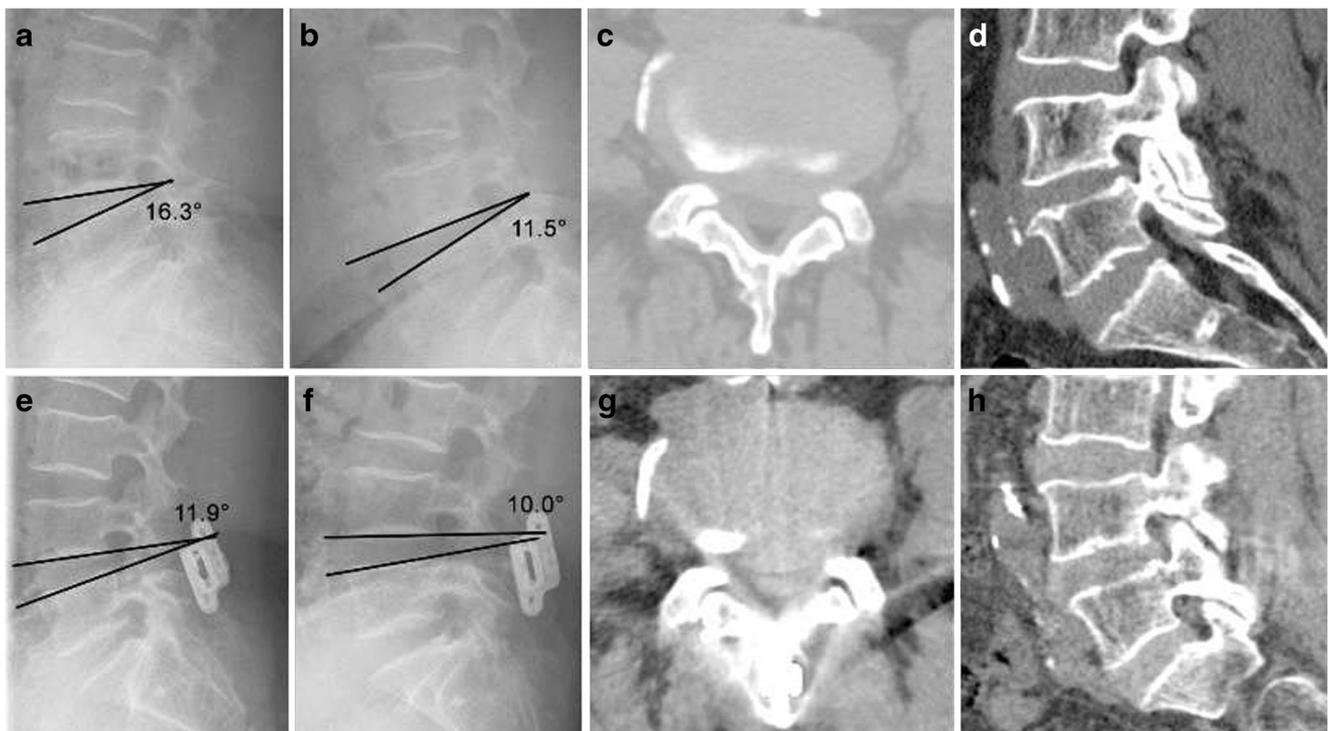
The patient was a 64-year-old woman who complained pain in the left lower limb. Her pre-operation leg VAS and ODI were 6 and 36 and were 2 and 8 respectively at six months. a, b The pre-operative flexion and extension X-ray. The ROM was 4.8°. c The herniated disc in horizontal restructured image. d The foramen in sagittal restructured image. e, f
